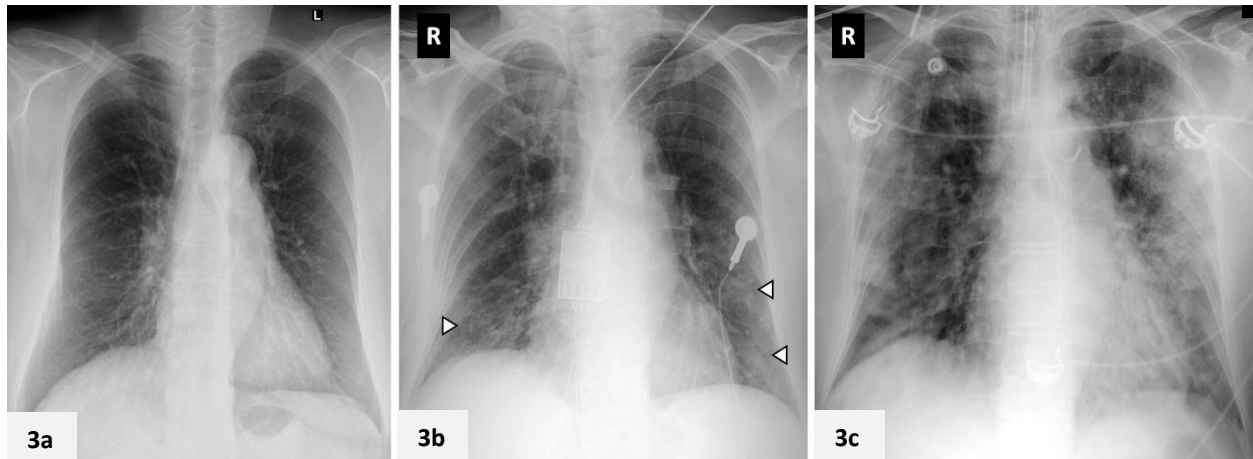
A 77-year-old woman with fever, cough and sore throat for 5 days. (a) Initial chest radiograph on admission is normal. (b) Follow-up radiograph performed 2 days later shows interval development of multifocal ground-glass opacities in the bilateral lower zones (arrowheads). The patient deteriorated during admission and required intensive care admission for mechanical ventilation. (c) Radiograph obtained on Day 11 of admission shows progression of lung changes with multifocal bilateral lung consolidation, worse in the left lung.
